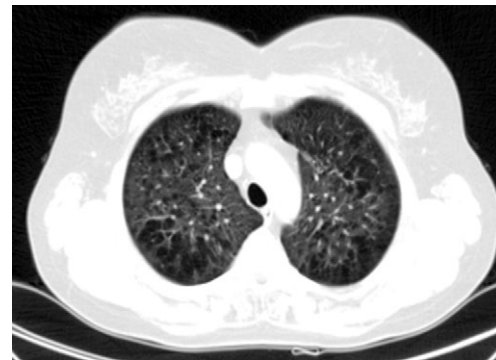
CT scan of the thorax: improvement of lesions.
